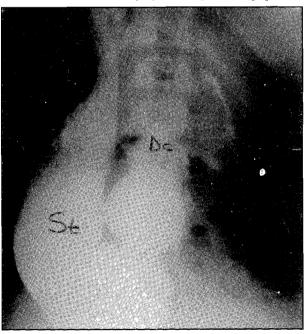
Barium meal and follow through exam showing the stomach (St) on the right, the duodenal cap (Dc) more rightward, and the C-loop (DCL) on the left. The marker (L) is on the top left corner of the radiograph.
